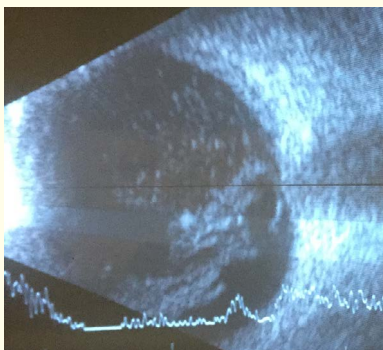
B-scan ultrasound of the left eye shows significant amount of vitreous debris, but no masses nor retinal detachment.
